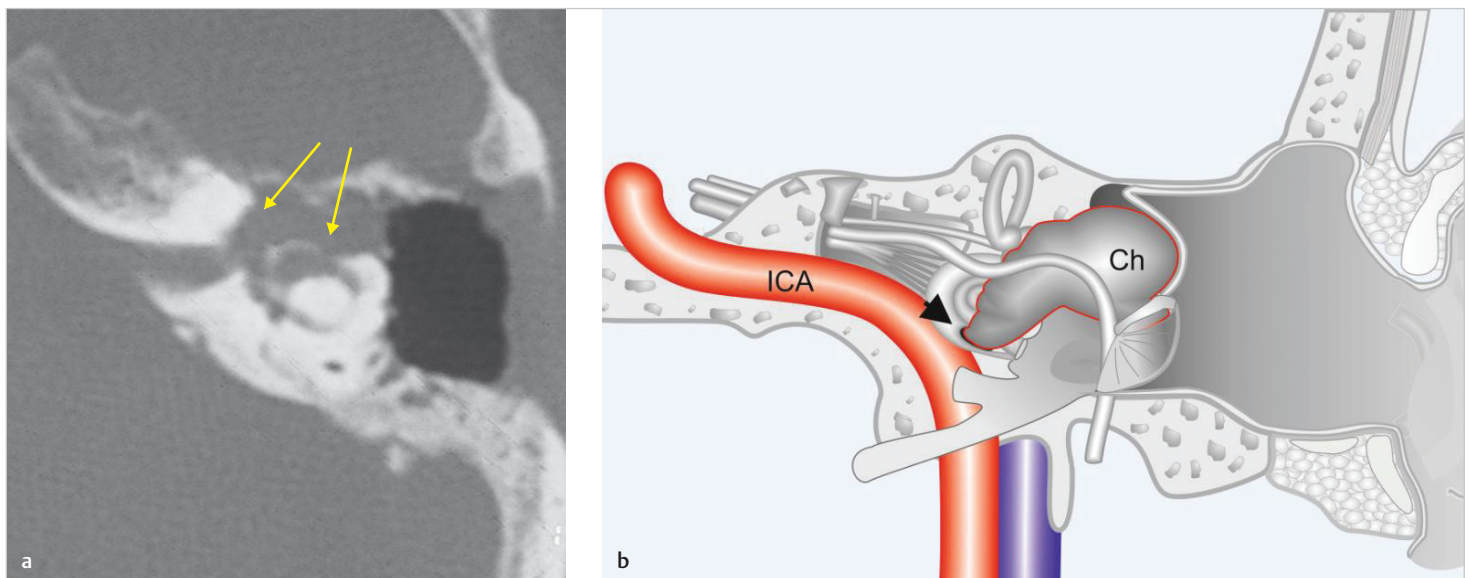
(a) CT scan of the same case, axial section. Involvement of the lateral semicircular canal and the vestibule (arrows) is well visualized. (b) The cholesteatoma invades the cochlea anteriorly, while medially it reaches the fundus of the internal auditory canal. The posterior semicircular canal is not invaded.
